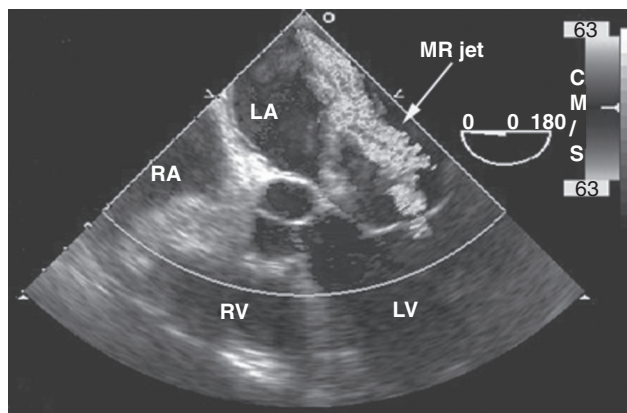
■ Severe mitral regurgitation (MR). Transesophageal five-chamber view shows severe mitral regurgitation with a large regurgitant jet (arrow) going far posteriorly in the left atrium (LA). In this case, systolic flow reversal in the pulmonary veins (another echocardiographic sign of severe mitral regurgitation) also was present (not shown on this picture). Because of its close anatomic proximity, transesophageal echocardiography is an excellent tool for the precise evaluation of the degree of mitral regurgitation. LV, left ventricle; RA, right atrium; RV, right ventricle.
